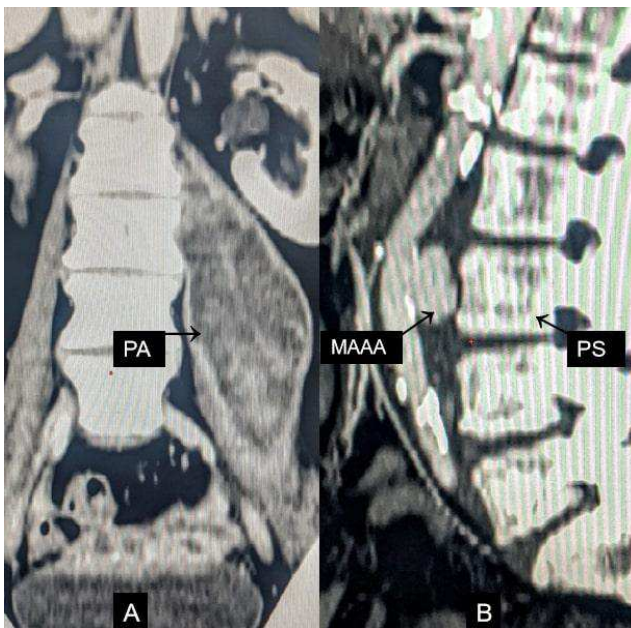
CT scan of the coronal (A) and sagittal (B) sections revealing, left psoas abscess (PA) pseudoaneurysm (MAAA) arising from the posterior wall of abdominal aorta and Pott's spine (PS).
